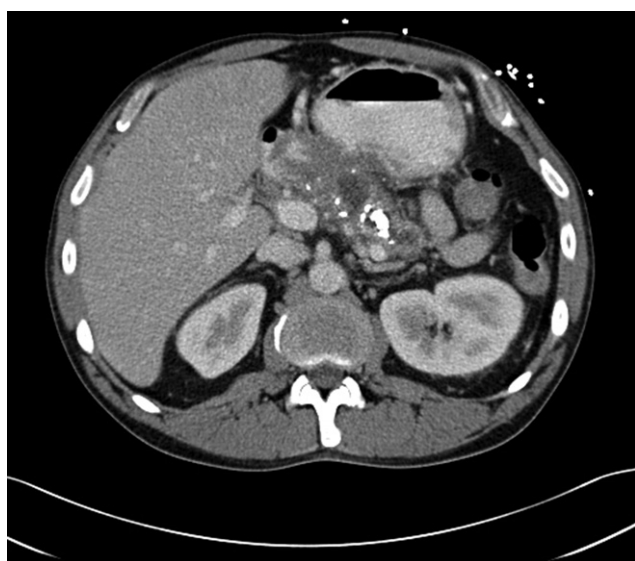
CT scan shows a dilated pancreatic duct and a large pancreatic calcification.
